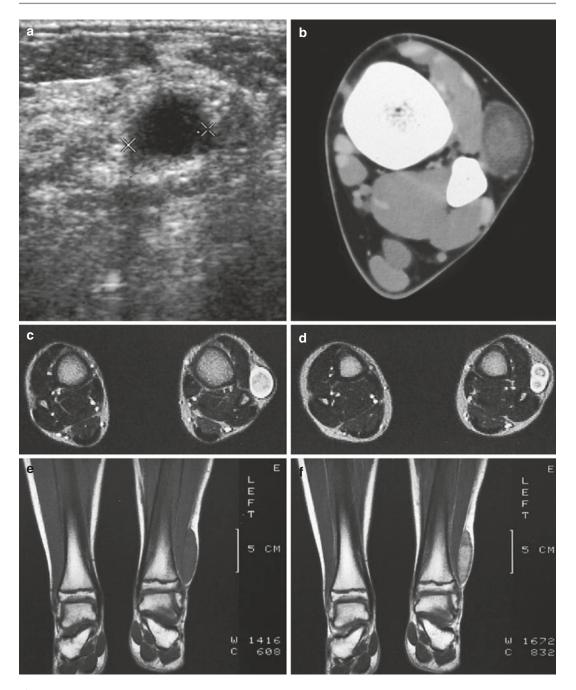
(a–f) Neurofibroma of the cutaneous tributary of the left superficial fibular nerve in a 14-year-old boy: (a) axial ultrasound image 8 cm proximal to the left fibular malleolus shows a well-circumscribed anechoic mass. (b) CT scan after iodinated contrast injection, proximal to the left ankle joint, confirmed the mass lesion in the subcutaneous fat next to the extensor digitorum longus muscle. The central part of the lesion shows a slightly higher density than the peripheral rim (target appearance). (c) T2-WI 7 cm proximal to the ankle joints confirms the target appearance, with a central area of moderately high signal intensity surrounded by a rim of extremely high signal intensity. (d) On axial T2-WI 3 cm proximal to the ankle joints, there is bifurcation in the inferior part of the lesion. (e) Coronal T1-WI shows the tumor to be isointense relative to muscle. (f) On coronal T1-WI after gadolinium contrast injection, there is central tumor enhancement
